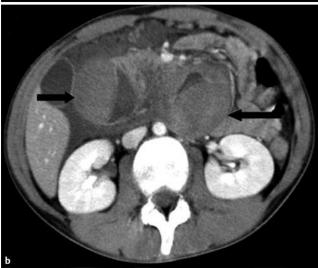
Both the abdominal computed tomography images, without contrast (a) and with contrast (b), disclosed diffuse intramural hematoma (arrows) of the duodenum, extending from the first portion to the fourth portion.
